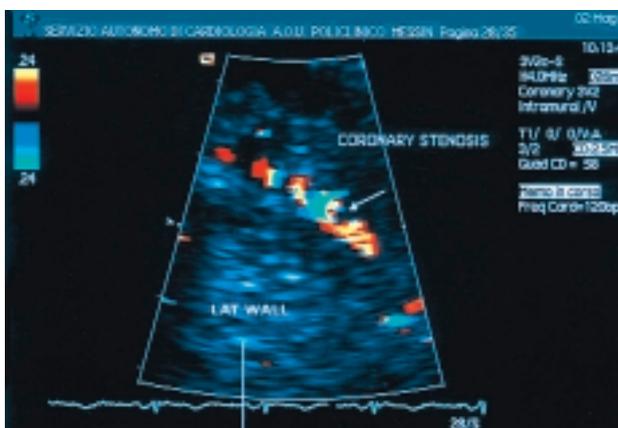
Echocardiographic magnification of the stenotic left anterior descending coronary segment (arrow). Abnormal flow velocity pattern resulting in color Doppler aliasing.
